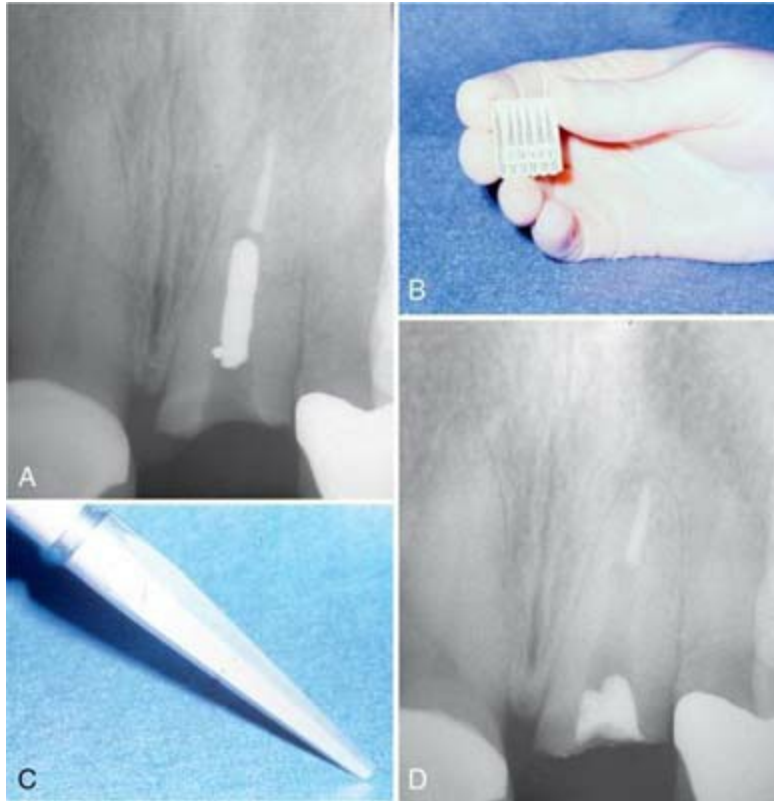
A, Radiograph of fractured post. B, Roto-Pro Kit. C, Roto-Pro Bur. D, Post removed by vibration of the instrument alone.
